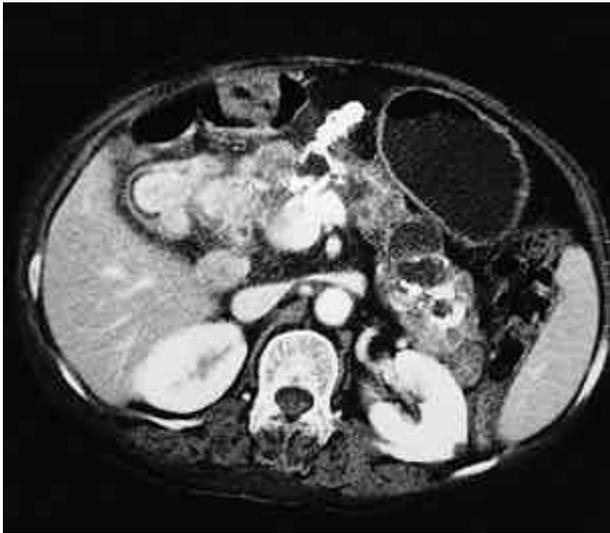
Abdominal computed tomography (CT) scan reveals numerous varying sized cysts throughout pancreas and a well enhanced mass in the head, which invades to the duodenum.
